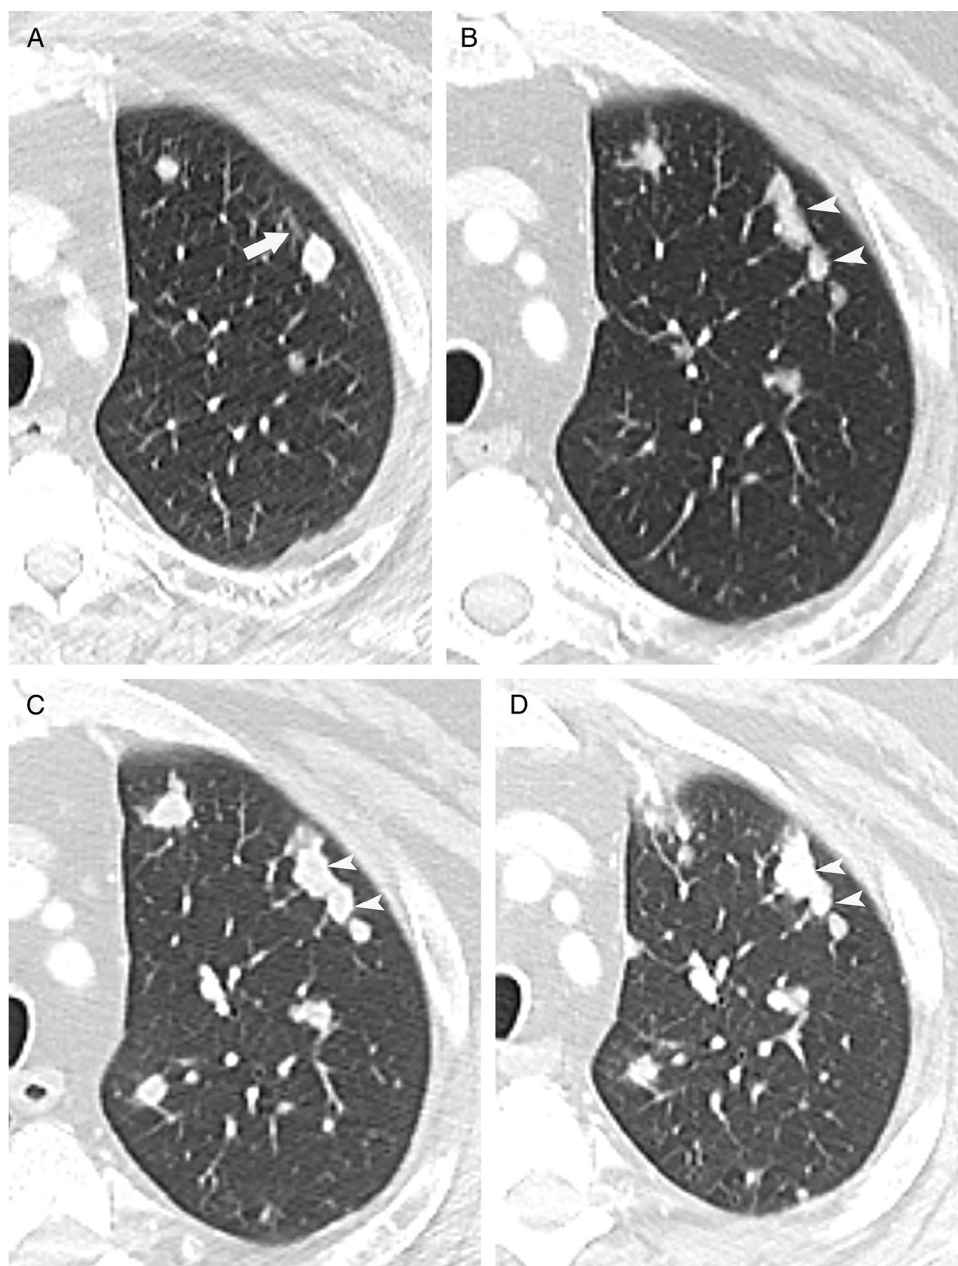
A 65-year-old man with metastatic renal cell carcinoma with an increase in thickness and nodularity of a biopsy tract consistent with malignant seeding. (A) Axial computed tomography (CT) image 6 weeks after biopsy shows a linear tract (arrow) that corresponded to the biopsy needle path. (B) Axial CT image 7 months after (A) shows thickening and nodularity of the tract (arrowheads). (C) Axial CT image 11 months after (A) shows increasing thickening and nodularity of the tract (arrowheads). (D) Axial CT image 14 months after (A) shows further thickening and nodularity of the tract (arrowheads). Note the overall increase in the size and number of lung metastases.
